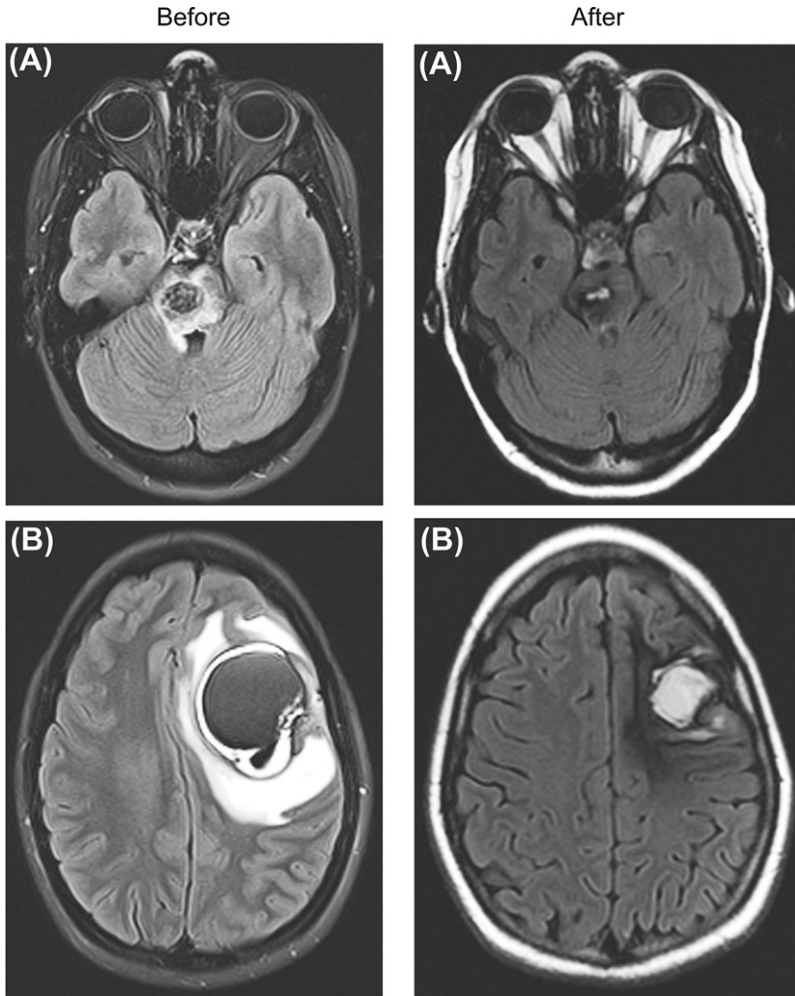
Clinical response of *BRAF*-mutant melanoma brain metastases with vemurafenib therapy. *Left*: baseline MRI of the brain showing symptomatic, progressive brain metastases following previous stereotactic radiosurgery. *Right*: MRI of the brain following treatment with vemurafenib for 6 months. (Reprinted with permission from The New England Journal of Medicine (Rochet *et al.*, 2011)).
